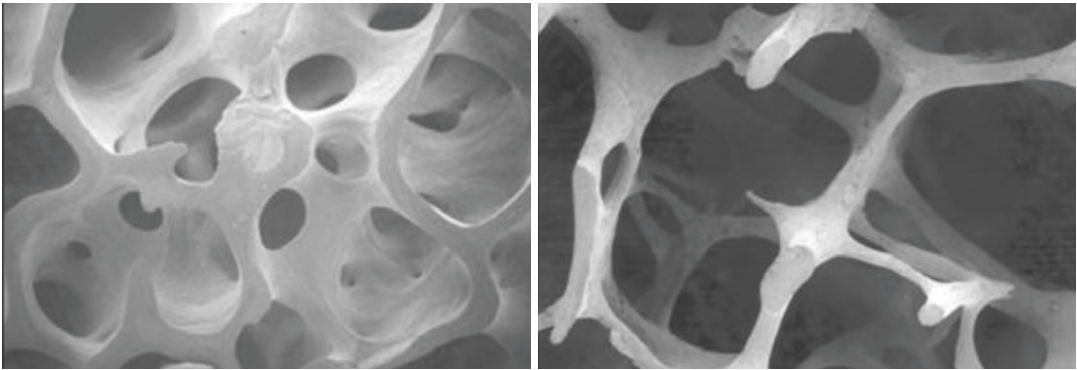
Three-dimensional computed tomography images of cancellous bone from a normal individual (left picture) and a patient with osteoporosis (right picture).
